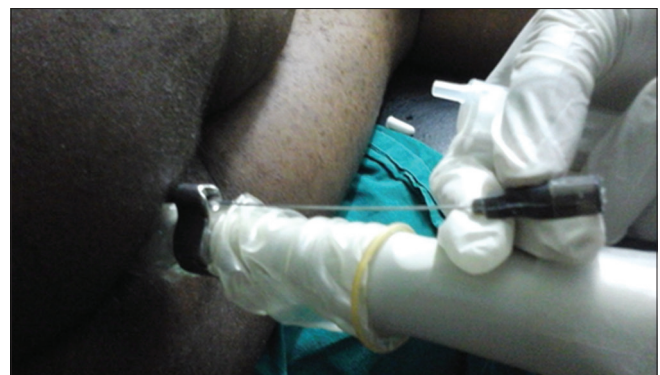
Transrectal ultrasound probe, needle guide and fine-needle *in situ* within the anorectum for preparation of fine-needle aspiration cytology
